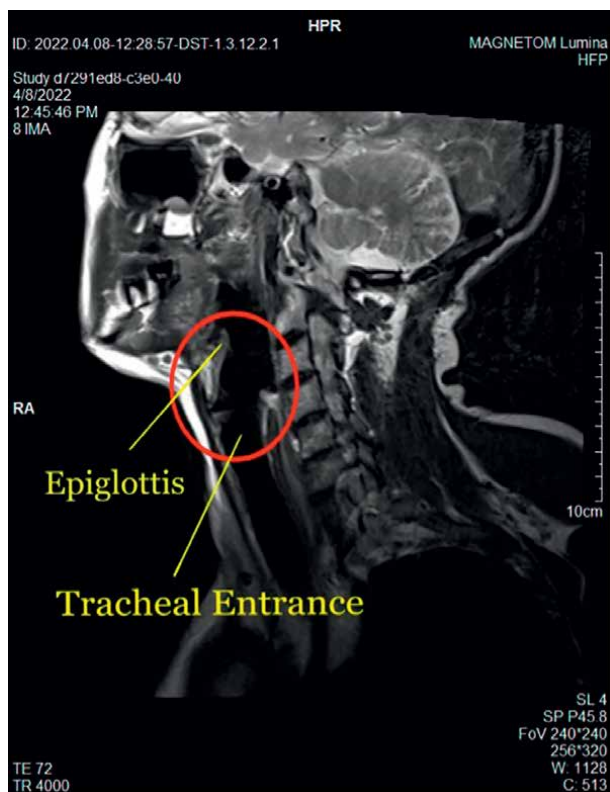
MRI image of prone position with head turned to the right side (courtesy of Special Hospital AGRAM, Zagreb, Croatia).
